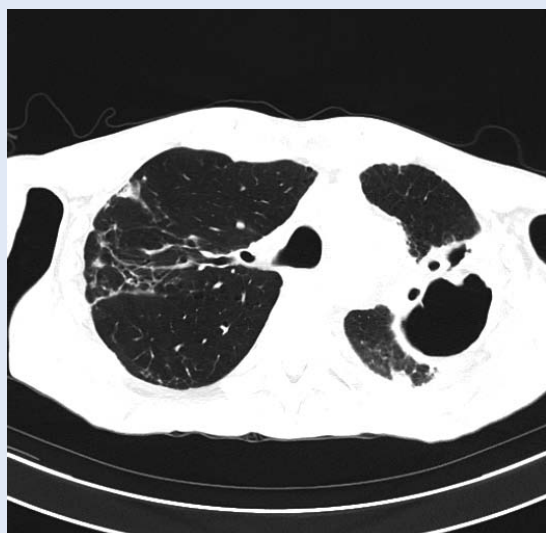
CT thorax scan (March 2017)
